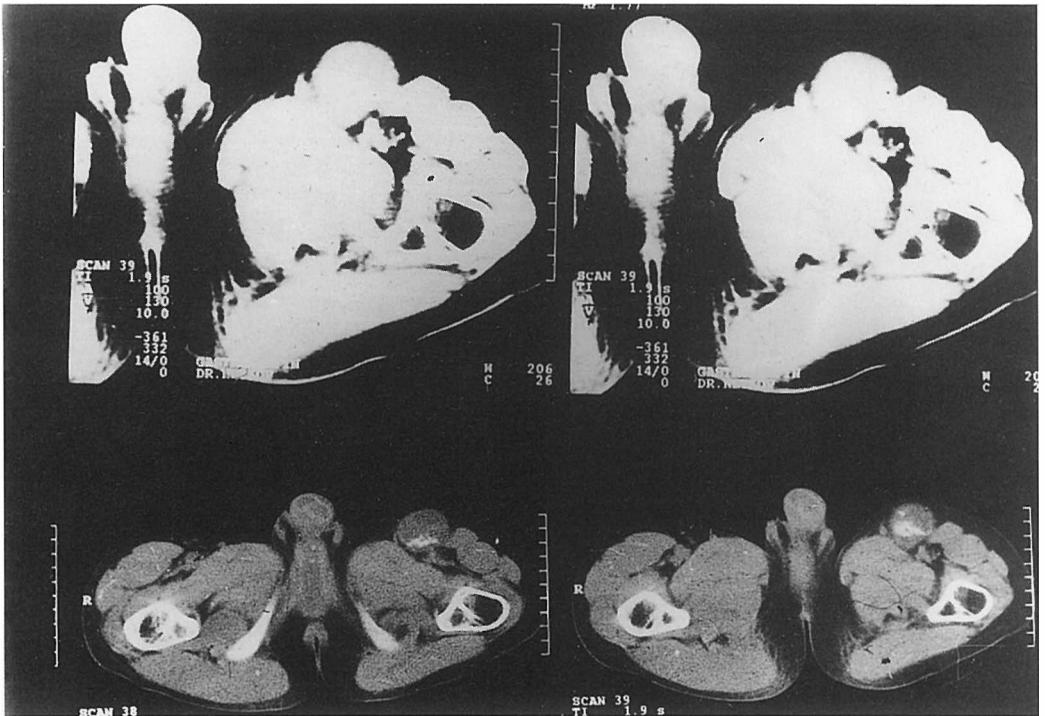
CT of the pelvis (region of the left groin).
